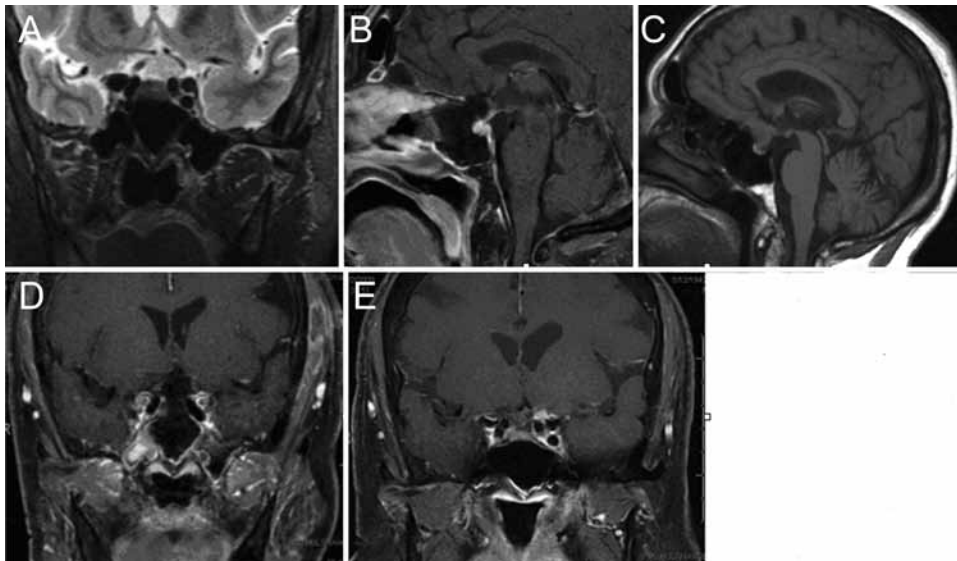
Case 13. Preoperative coronal T2-weighted (A) and sagittal contrast-enhanced T1-weighted (B) MR images showing a TSM attached to the tuberculum sellae and compressing the optic nerves and chiasm. After an NTR via ETSA, sagittal (C) and coronal (D) fat-suppressed, contrast-enhanced T1-weighted MR images were obtained, demonstrating no evidence of residual tumor, although a small tumor capsule was seen on the carotid artery intraoperatively. Three years after TSM removal, the patient presented again with recurrent visual loss in the left eye. Coronal fat-suppressed, contrast-enhanced T1-weighted MR image (E) showing tumor above and lateral to the optic nerve. The patient underwent TCR with NTR of the TSM.
